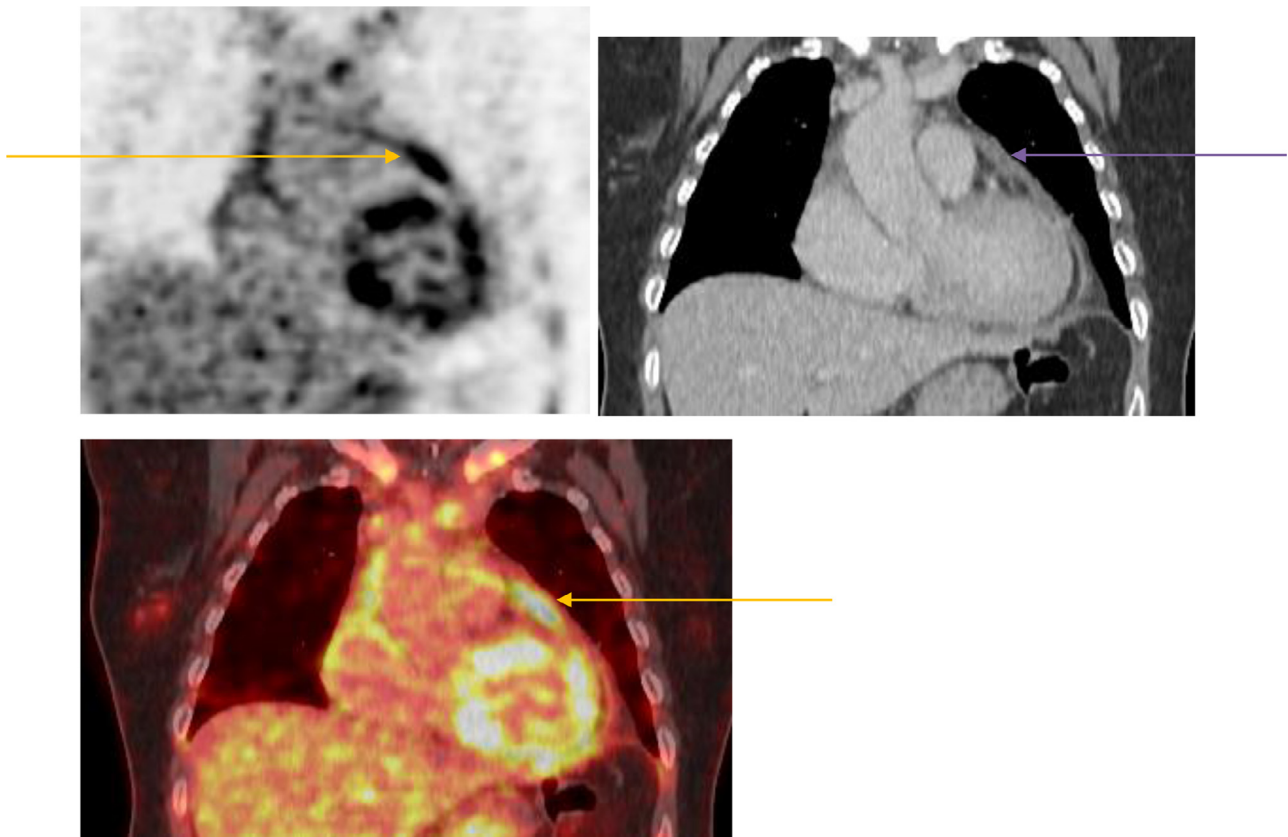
Coronal sections for PET [upper left], CT [upper right] and fused PET-CT [lower] images showing increased FDG uptake in the thickened pericardium SUV max = 6.9 (arrows). Please compare with MRI coronal view in image 4.
